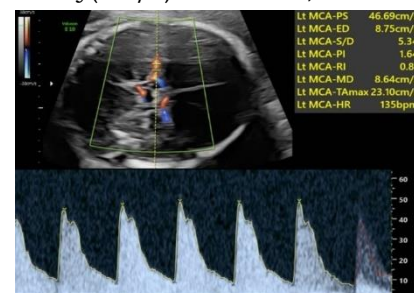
Acquisition of MCA Doppler flow. Note the use of the fetal suture as a window to capture MCA flow with minimal angle correction.Melber,⁹
